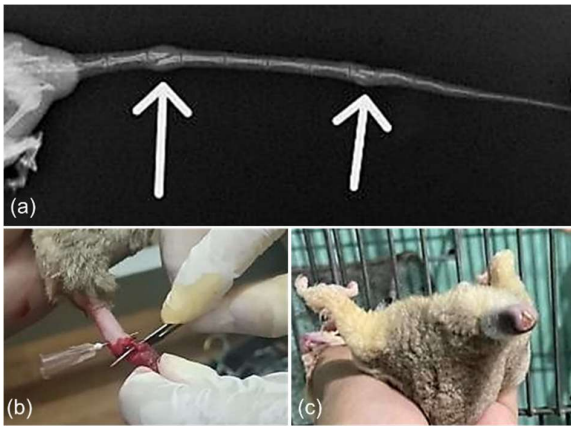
Coccygeal fracture and surgical management of tail injury in a sugar glider. (a) Lateral radiograph showing a coccygeal vertebral fracture at the distal tail segment (white arrow). (b) Intraoperative appearance during tail amputation. (c) Wound healing progression at 7 days postoperatively.
